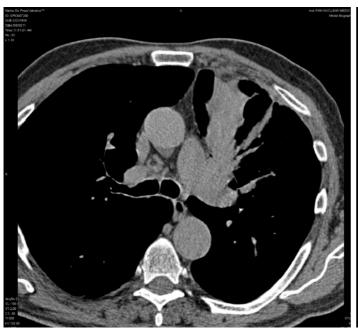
Breath-hold CT of Patient 1
